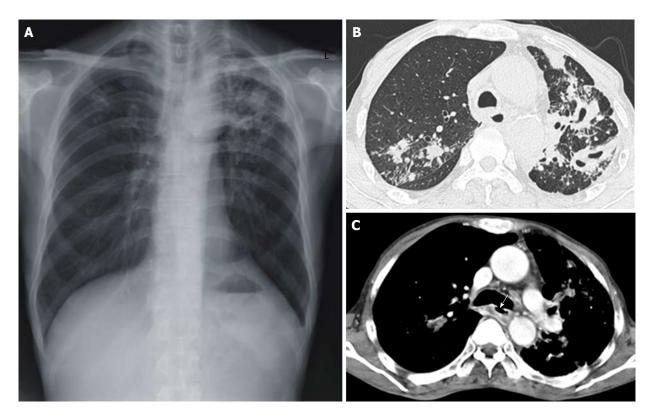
Chest radiograph and chest computed tomography scans are suggested reactivated pulmonary tuberculosis. A: Chest radiograph revealing combined reticulonodular densities, air space and nodular consolidation in the both upper lobe of the lung; B: Chest computed tomography showing multiple cavities with centrilobular nodules in the left upper lobe of the lung; C: A 1 cm sized bronchoesophageal fistula (white arrow) was observed in the inferior wall aspect of the left main bronchus.
